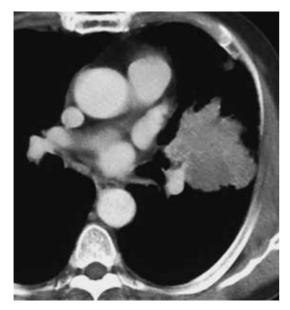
Chest CT scan showing a mass in the left lingula. Invasion to the lower lobe and pulmonary artery was suspected.
